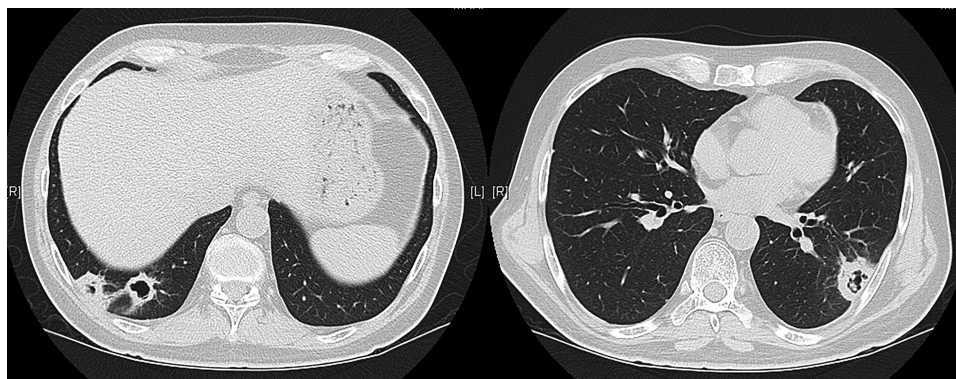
Computed tomographic scan of the chest demonstrating multiple cavitary lung nodules.
